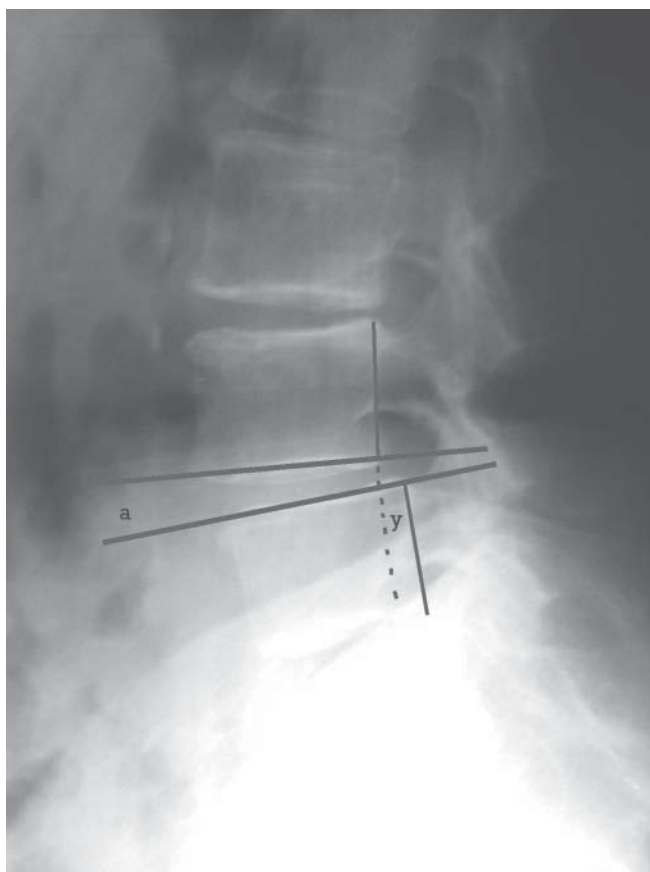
A lateral radiograph of the lumbar spine of a patient with degenerative spondylolisthesis. Two lines were drawn: one was tangent to the lower endplate of the upper vertebra and the other was tangent to the upper endplate of the subadjacent vertebra. The angle a indicates the angle between the two vertebrae. The change in angle a between maximal flexion and maximal extension states indicates the angular displacement between the two vertebrae. The distance y is the amount of forward vertebral slippage on the subadjacent vertebra. The change in distance y between maximal flexion and maximal extension states indicates the sagittal displacement between the two vertebrae
